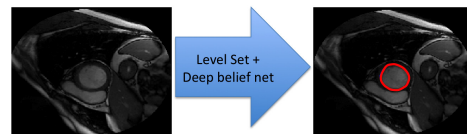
Proposed methodology for cardiac MRI segmentation.
